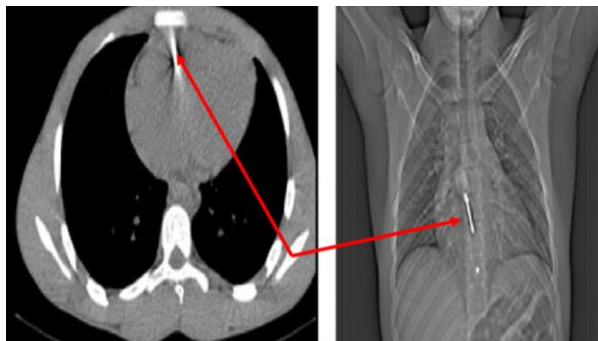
Imaging (CT scan on the left and chest X-ray on the right) showing the foreign object within the heart.
